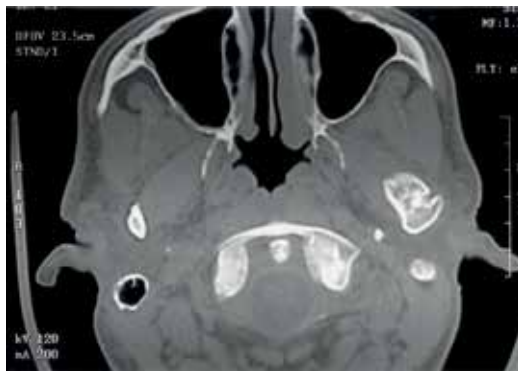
Axial CT scan, showing a well-defined, opaque mass.
